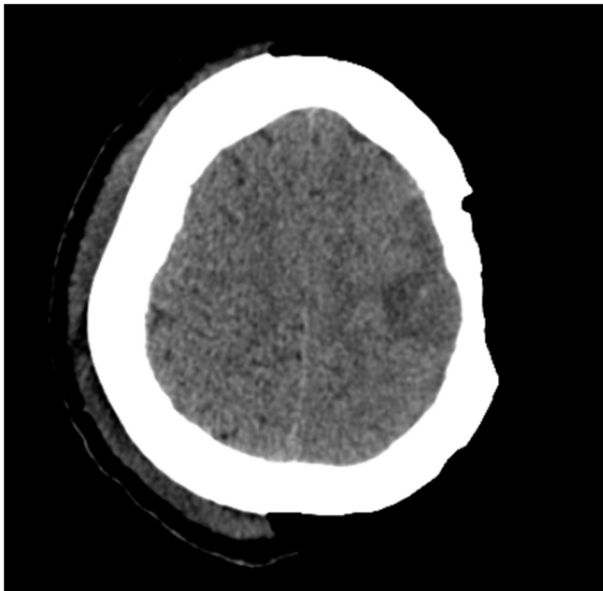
Contrast axial CT brain scan showing on the left erosion of the outer cortex of the parietal convexity and subcortical low density in the region of the left lateral precentral gyrus. These appearances are in keeping with osteomyelitis with an underlying focal encephalitis.
